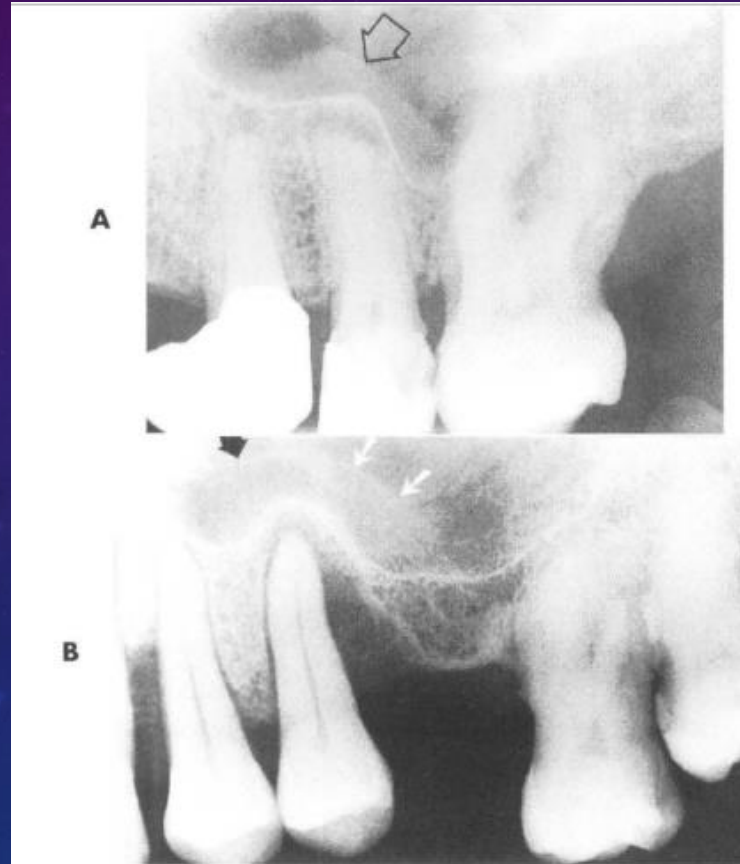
Hyperplasia of the soft tissue membrane of the maxillary sinus floor (*arrows*). A, Etiology is a pulpoperiapical infection involving the second premolar tooth. B, Etiology is advanced periodontal disease involving the second premolar tooth.
